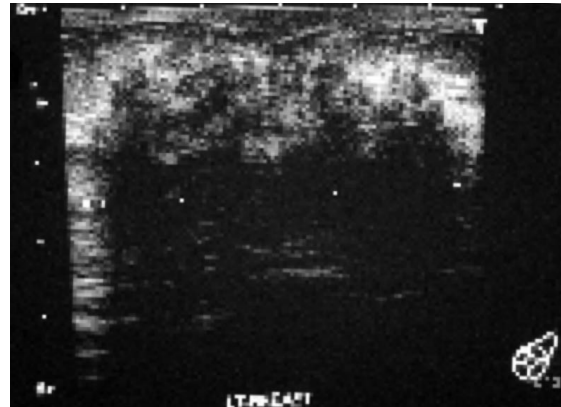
Ultrasonographical image of the left breast shows posterior acoustic shadowing.
